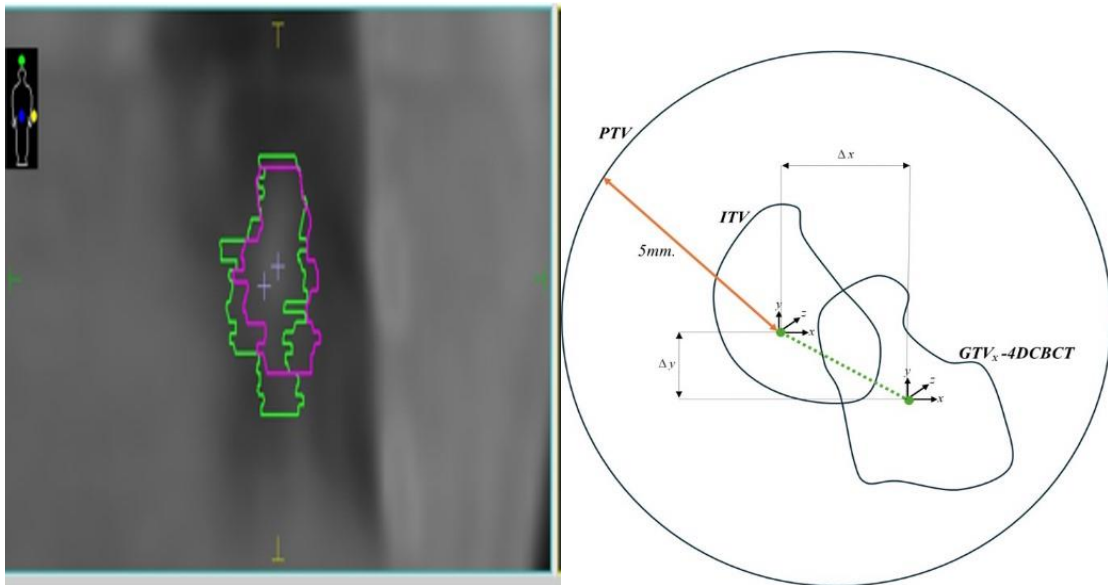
The variation between centroid positions of ITV and GTV_{4DCBCT} in (x-y) coordinates
